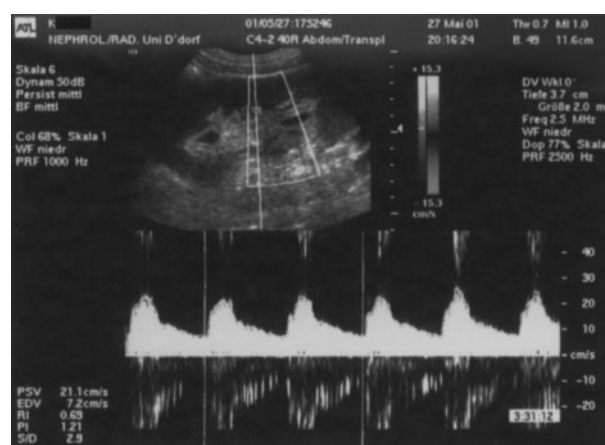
Doppler sonographic findings after surgical revision for suspected transplant vein thrombosis.
